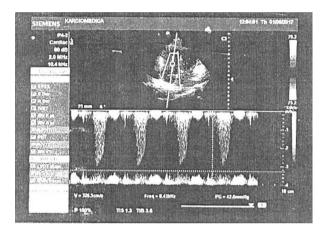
Continuous wave Doppler. Tricuspid regurgitation. Right ventricular systolic pressure estimated at 42.6 mm Hg based on the velocity of the tricuspid regurgitant jet (plus central venous pressure to give estimated pulmonary artery systolic pressure)
